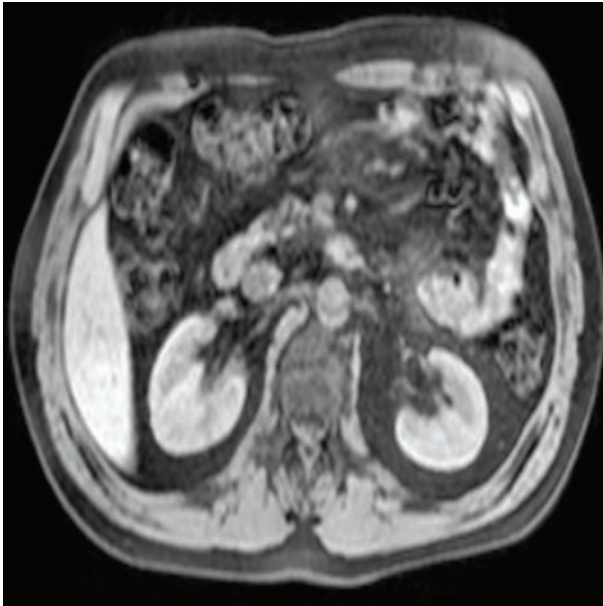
This axial contrast enhanced MRI image of abdomen during the late phase shows the presence of a mesenteric mass with contrast enhancement. The contrast enhancement is typically more evident in the late phase and more evident in the forms with a greater fibrotic component or in the fibrotic portions of the mass such as the pseudocapsula
